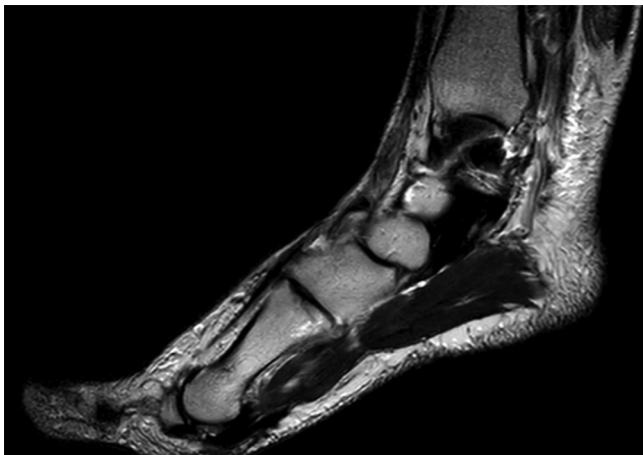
MRI picture showing avulsion of tibialis anterior.
